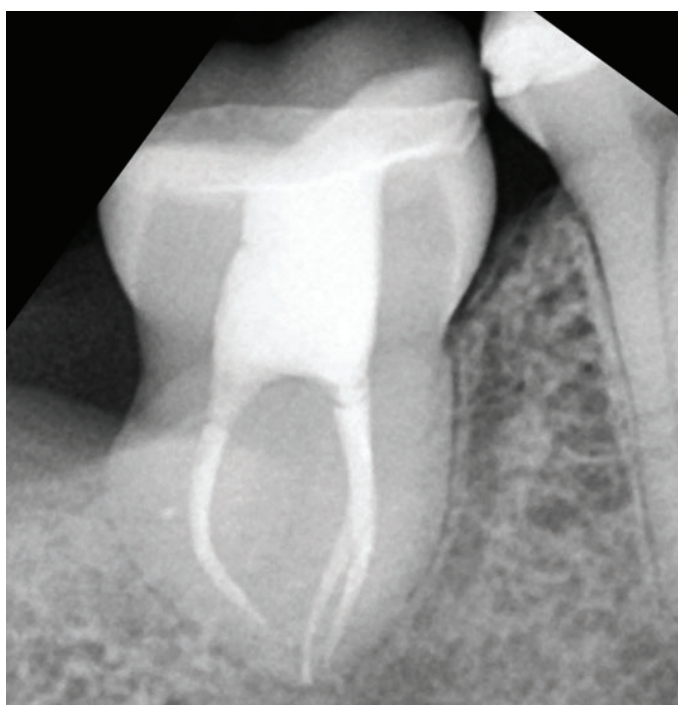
X-ray at the control period of 6 months demonstrated full integration of the transplanted tooth.
